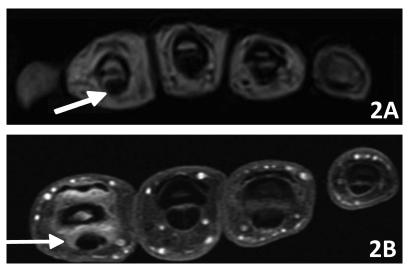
PIP joint tenosynovitis and synovitis (arrow) LF and HF MRI. The images demonstrate the difference in appearance at the same timepoint. The LF images demonstrate low-intensity enhancement, with the HF image showing greater thickness of enhancing synovium and greater intensity of enhancement. (A) Patient 6 baseline post-GAD LF PIP (score 1). (B) Patient 6 baseline GAD HF PIP (score 3). PIP: proximal interphalangeal; LF: low-field; HF: high-field; MRI: magnetic resonance imaging; GAD: gadolinium.
